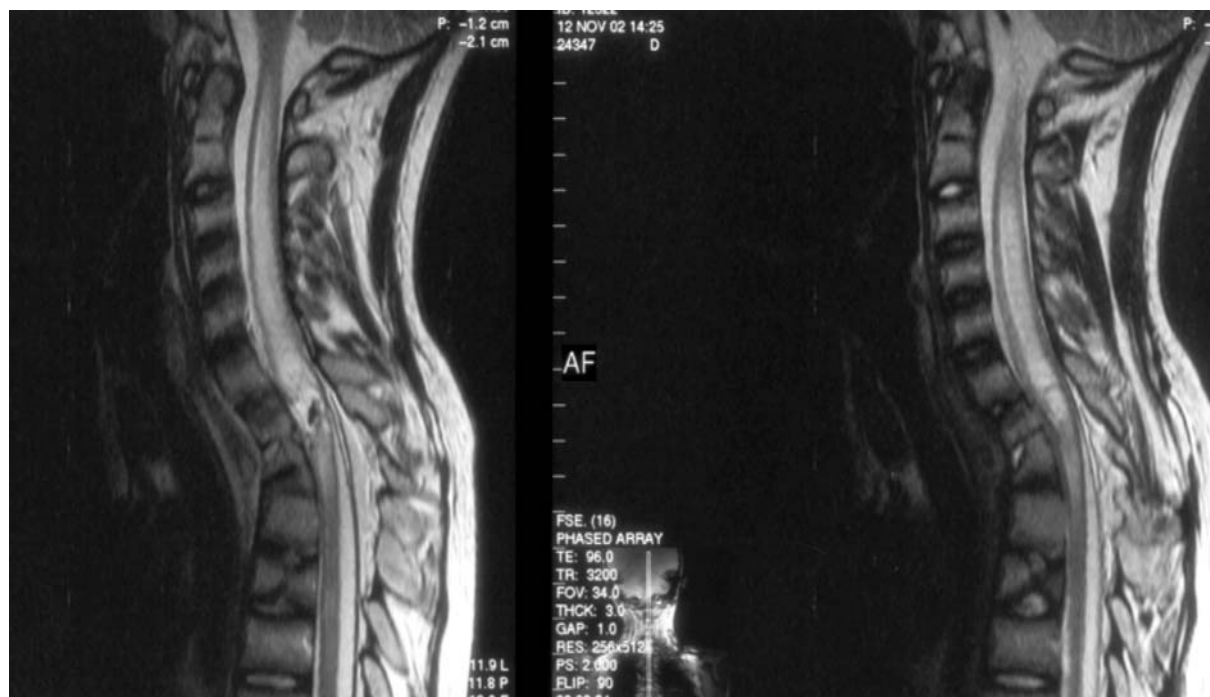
MRI scan (12.11.2002) showing further evolution of the lesion
